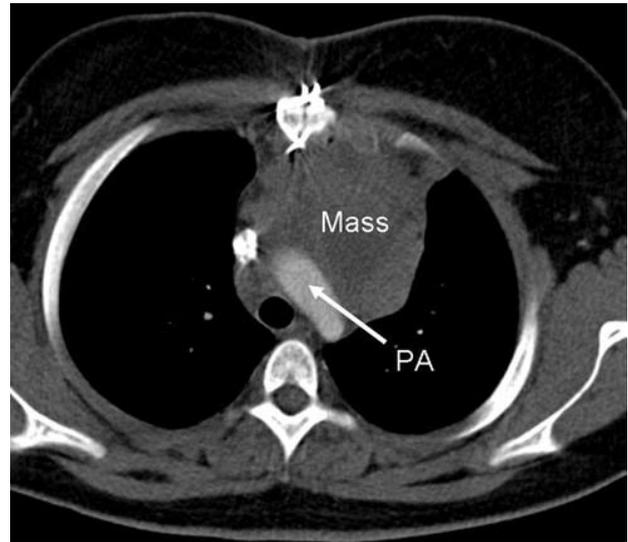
Computed tomography scan of the chest demonstrates an anterior mediastinal mass adjacent to the pulmonary artery (PA).
